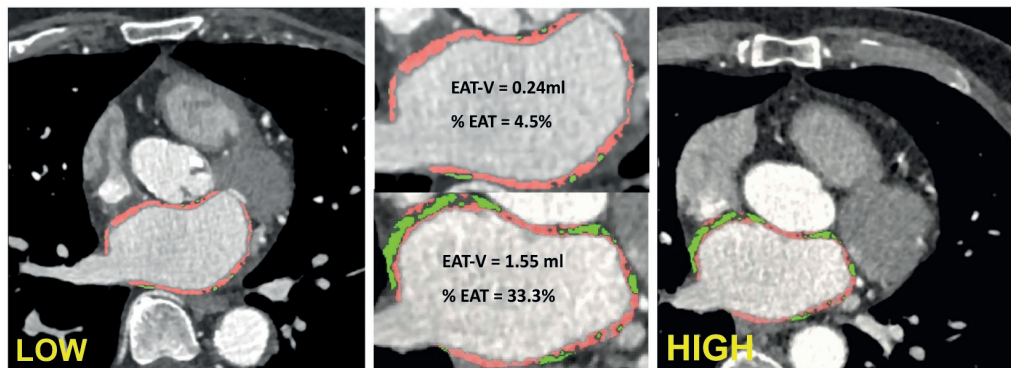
Differences in EAT-V (green) and MYO-V (red) between a low and high percentage of EAT in the LA wall, based on the Hounsfield Units. Left and upper middle: low EAT% in the LA wall (EAT-V=0.22 ml, MYO-V=4.63 ml, LA volume measured by TTE=103 ml, EAT%=4.5 %). Right and upper middle: high EAT% in the LA wall (EAT-V=1.55 ml, MYO-V=3.11 ml, LA volume measured by TTE=43 ml, EAT%=33.3 %). EAT-V=epicardial adipose tissue volume; MYO-V=myocardial volume; LA=left atrial; TTE=transthoracic echocardiogram.
